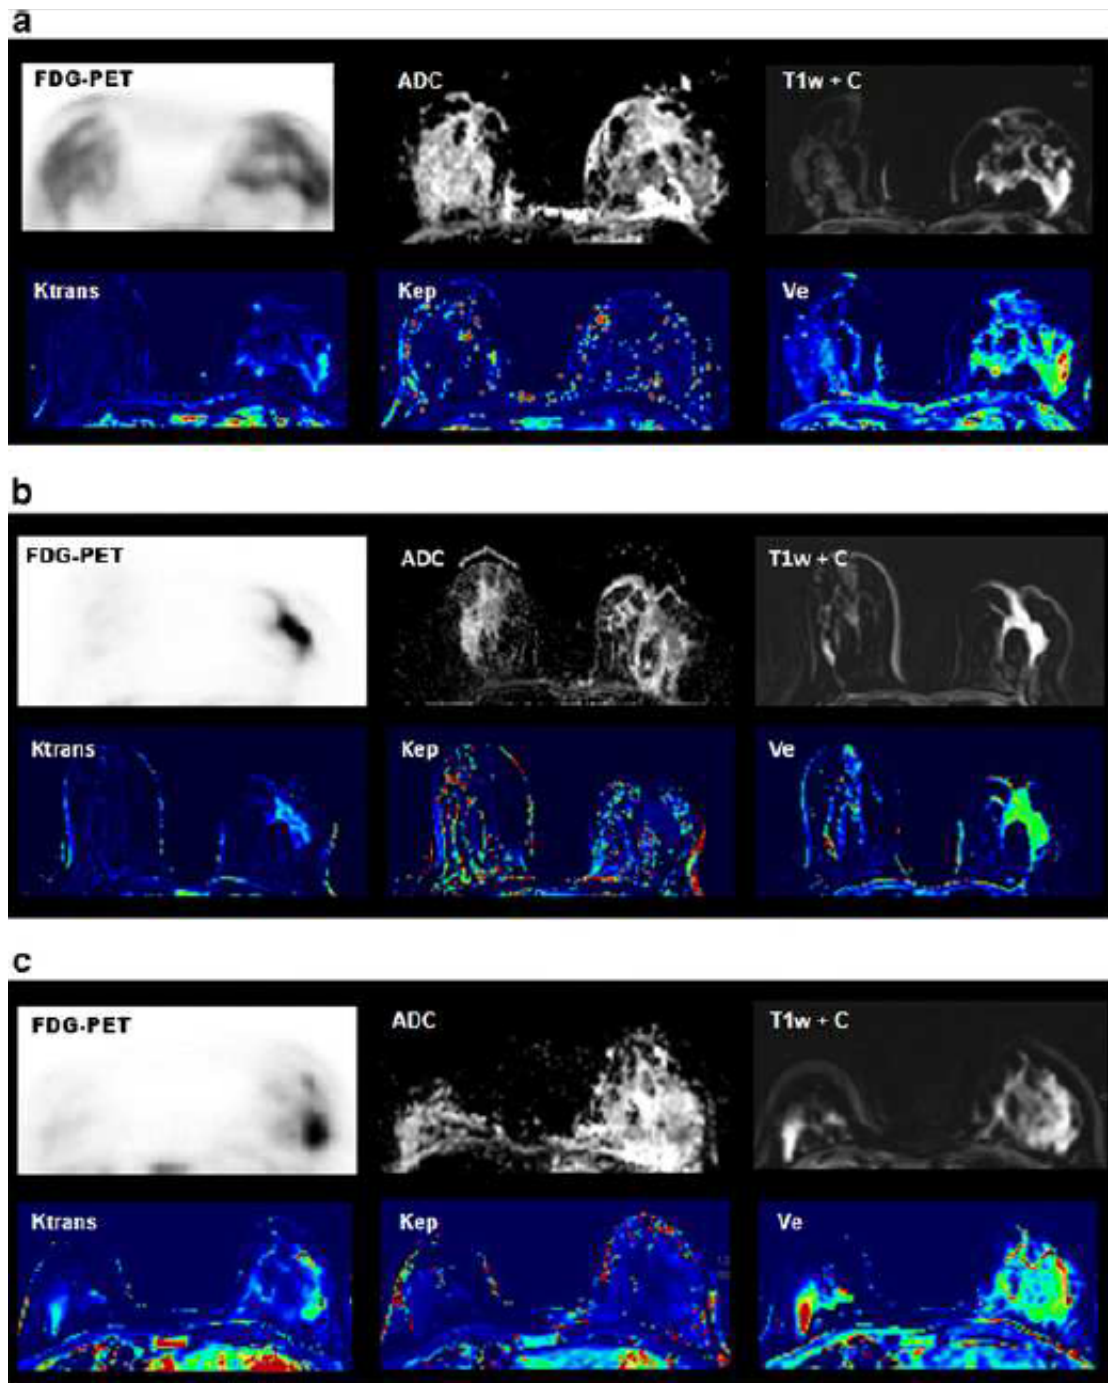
Examples of multiparametric analysis in women with breast ductal carcinoma. Multiparametric imaging evaluation of metabolic (PET), morphological (T1w + C), and functional (ADC, K^{trans} , v_e , k_{ep}) parameters in a luminal A BC (a), a luminal B BC (b) and a nonluminal BC (c). With increases in perfusion parameters, FDG uptake increases at the tumour site, enhancement increases in the morphological acquisitions, and diffusivity decreases in the ADC map.
